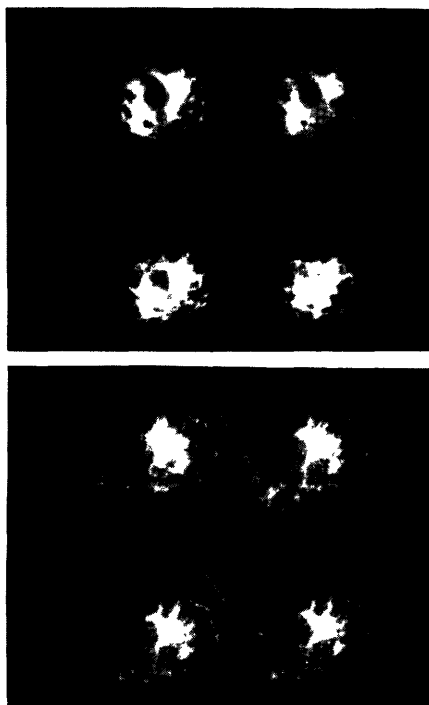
Ultrasonic computer-assisted tomograms through the breast of a patient with a 3 cm grade 4 infiltrating ductal carcinoma in the upper right inner quadrant. In fatty breasts ultrasonic computer-assisted tomography is very useful for detecting tumors and diagnosing their type. However, it was found in dense breasts that computer-assisted tomography was not capable of detecting or diagnosing cancer with adequate sensitivity and specificity. (Reproduced with permission from Greenleaf, J. F., et al., in *Acoustical Imaging*, E. A. Ash and C. R. Hill, eds., 12, pp. 579-587 (1982))
